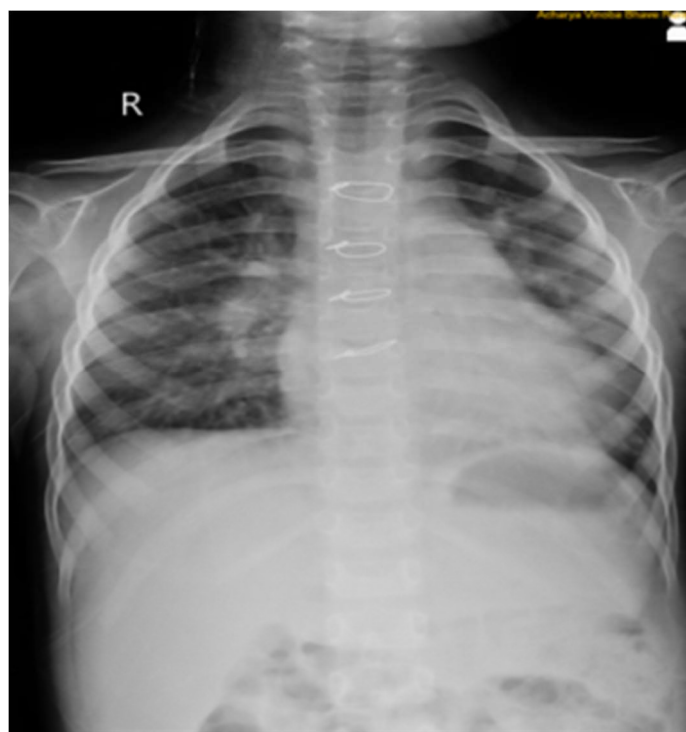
Shows the postoperative x-ray of the patient
